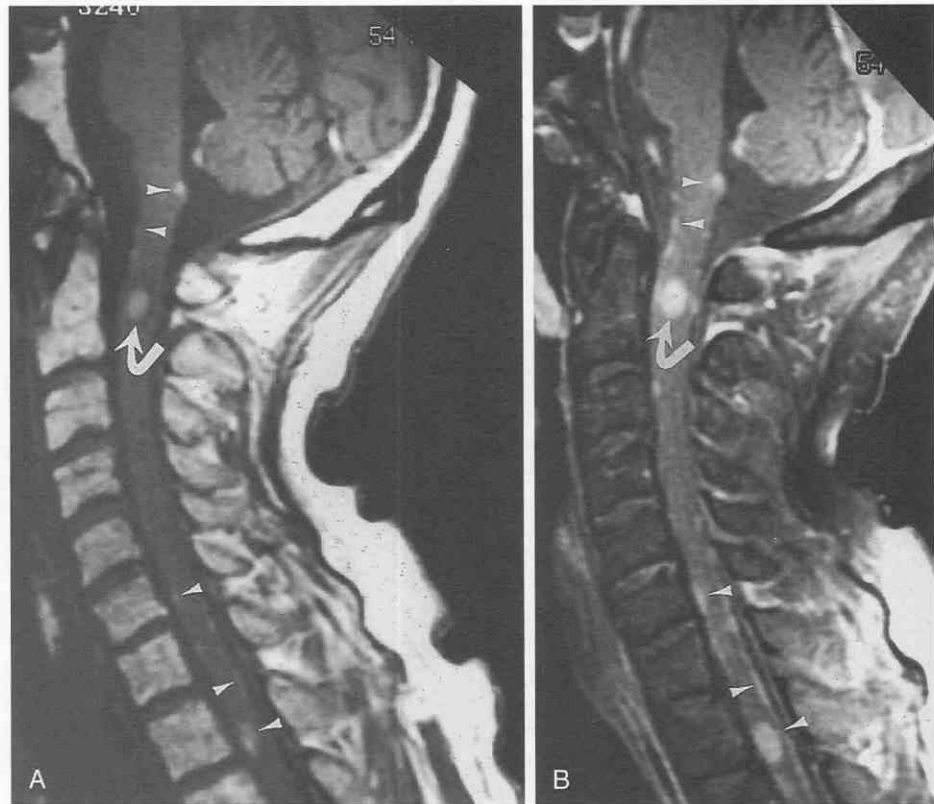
Primary leptomeningeal gliomatosis. This rare primary malignant meningeal neoplasm was diagnosed only at autopsy. There is both linear and nodular enhancement in a pia/subarachnoid space pattern (*arrows*) on a coronal image (*A*) and a sagittal enhanced T1-weighted image (*B*). (Courtesy of Bernhard C. Sander, M.D., and Tibor Mitrovics, M.D., Freie Universitätsklinikum Rudolf Virchow, Berlin, Germany.)
